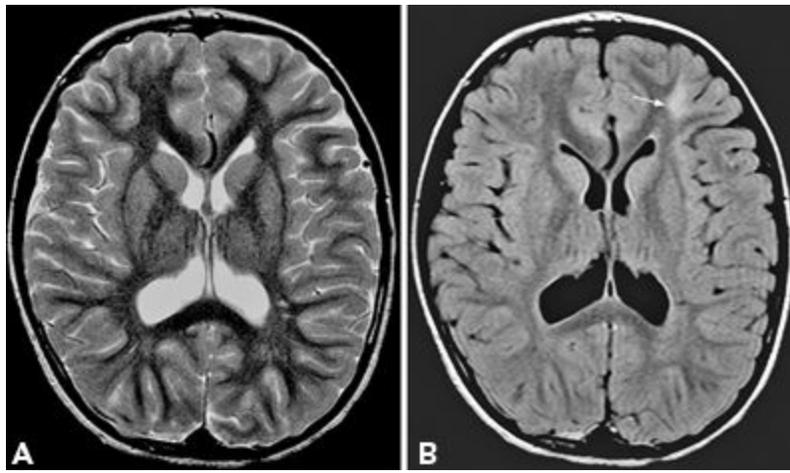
MR images to demonstrate superior visualization of subcortical hyperintensity associated with focal cortical dysplasia on FLAIR sequence. The dysplastic region in the left frontal region, nearly invisible on the T2-weighted image (A), is conspicuous (arrow) on the FLAIR image (B).
